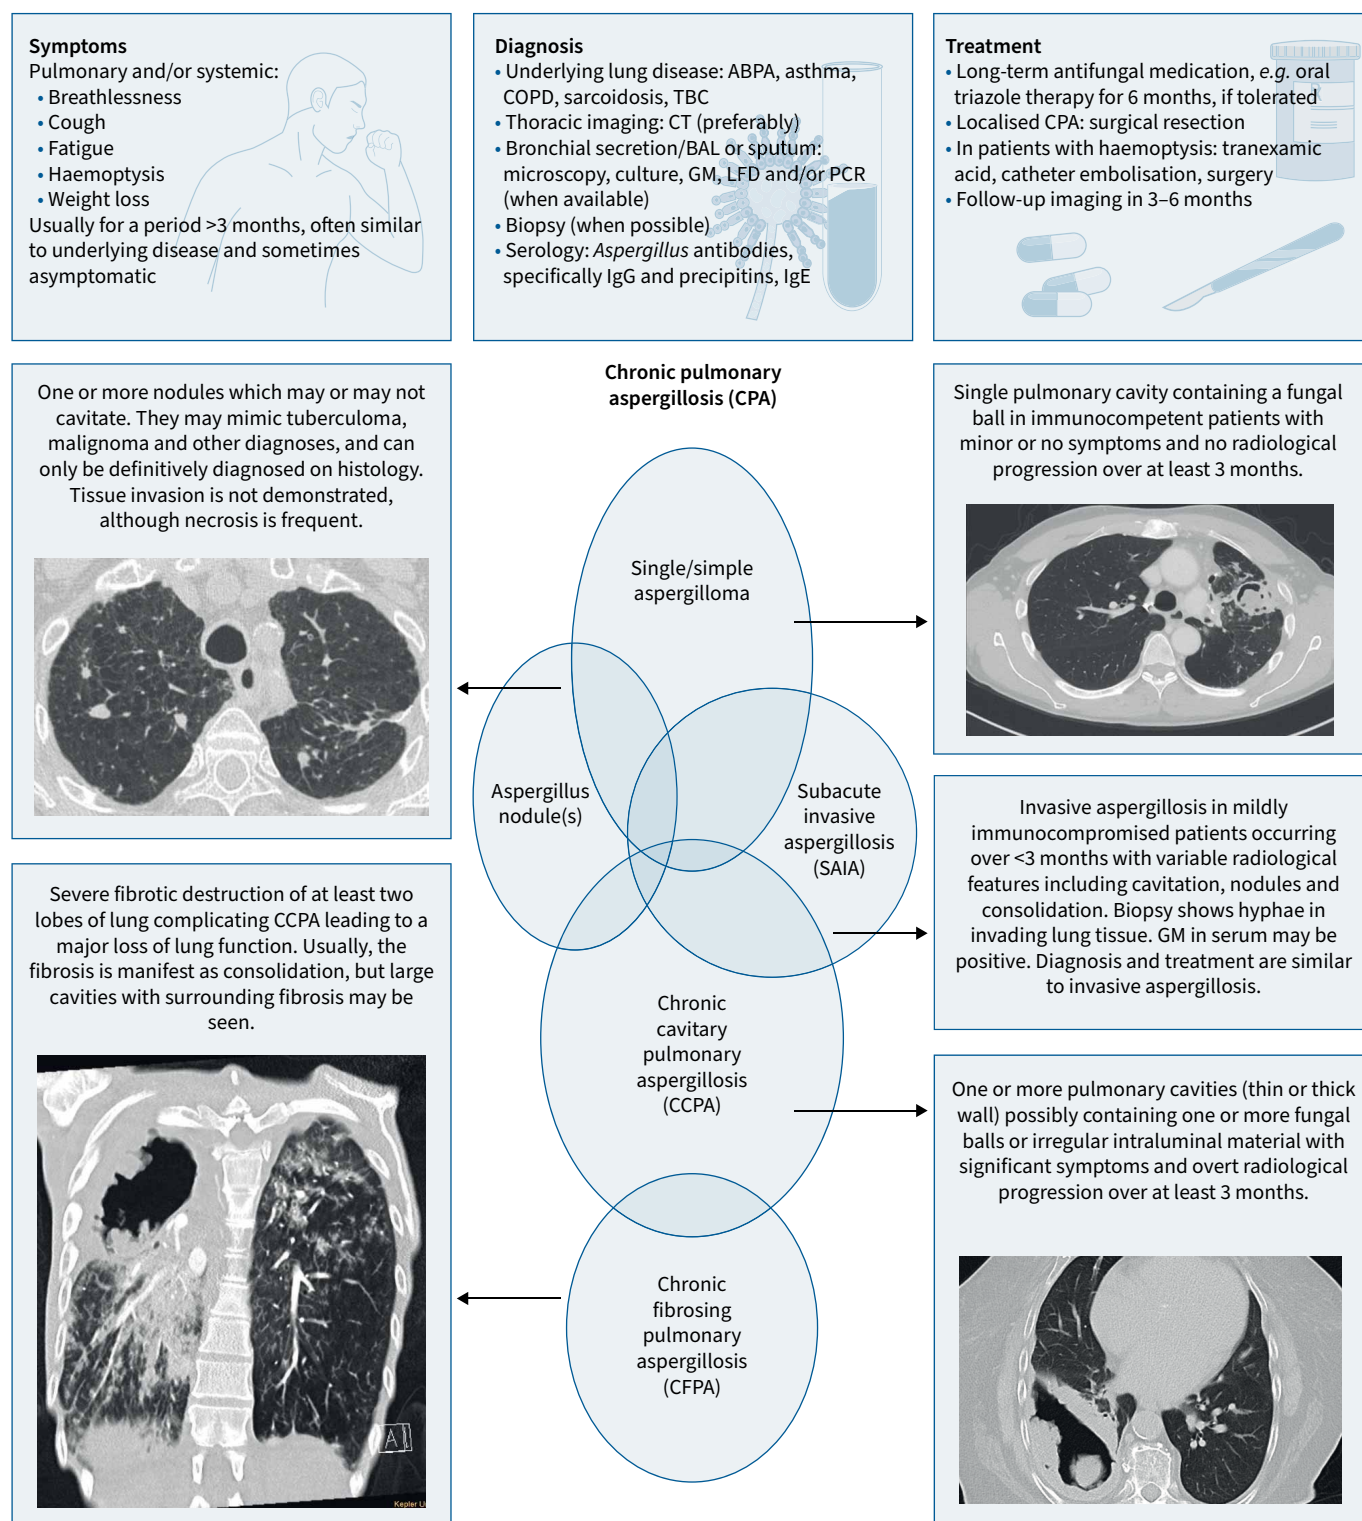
Diagnostic criteria and clinical management of chronic pulmonary aspergillosis (CPA). Considerable overlap exists in the clinical and radiological features between CPA phenotypes. CPA phenotypes and diagnostic criteria modified according to DENNING *et al.* [6]. The computed tomography (CT) scan showing *Aspergillus* nodules was published in SALZER *et al.* [24]. CT scans of CPA patients were contributed with kind permission by the Department of Pulmonology, Kepler University Hospital, Linz, Austria. ABPA: allergic bronchopulmonary aspergillosis; BAL: bronchoalveolar lavage; GM: galactomannan; LFD: lateral flow device; TBC: tuberculosis complex.
